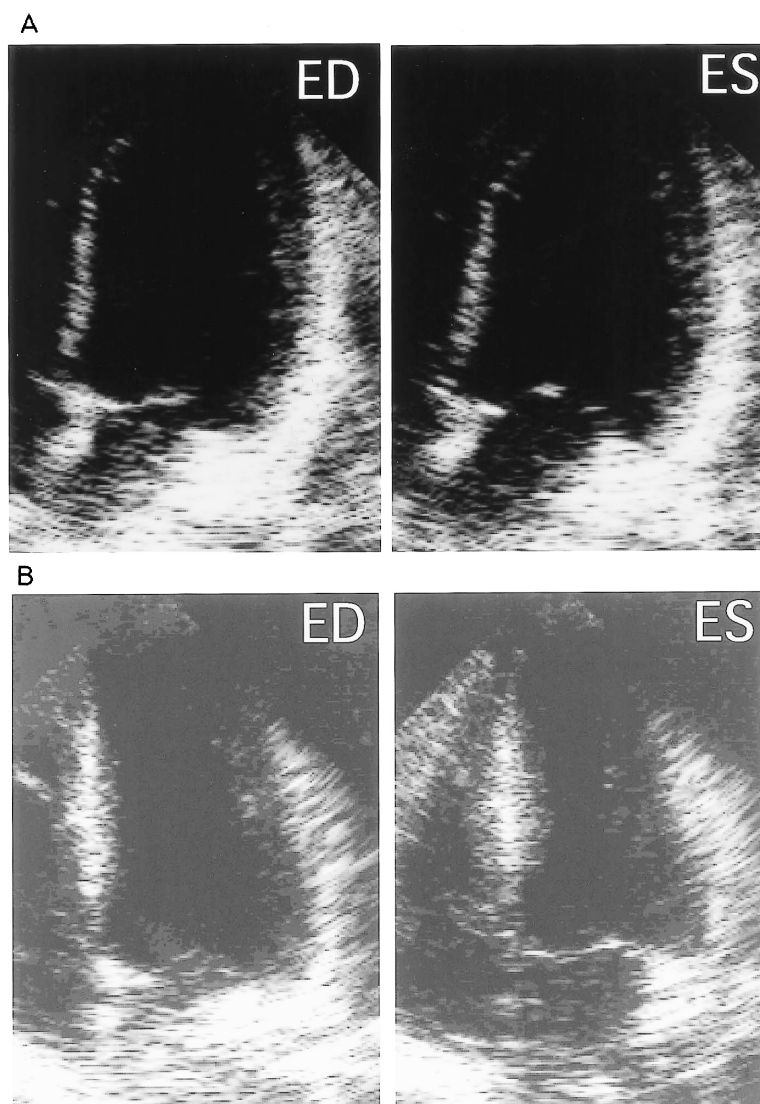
Apical four-chamber view echocardiograms on admission (A) and 28 days after admission (B) of Patient 4
